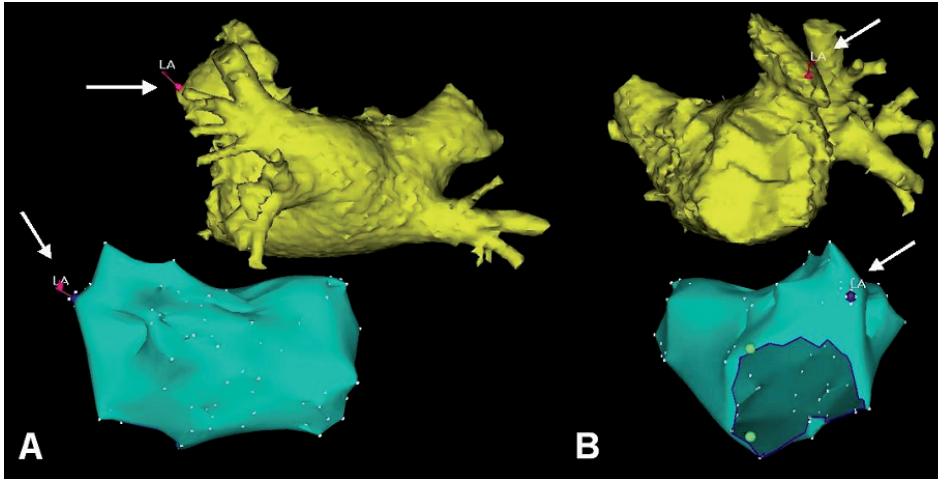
During the ablation procedure, a registration process was performed to fuse the electroanatomic map and the MSCT image. After completion of the electroanatomic map of the left atrium, landmarks were placed on the electroanatomic map and the MSCT surface image. In this case, a landmark (LA) was placed on the left atrial appendage, based on fluoroscopy and intracardiac echocardiography. Panel A: posterior view, Panel B: lateral view.
